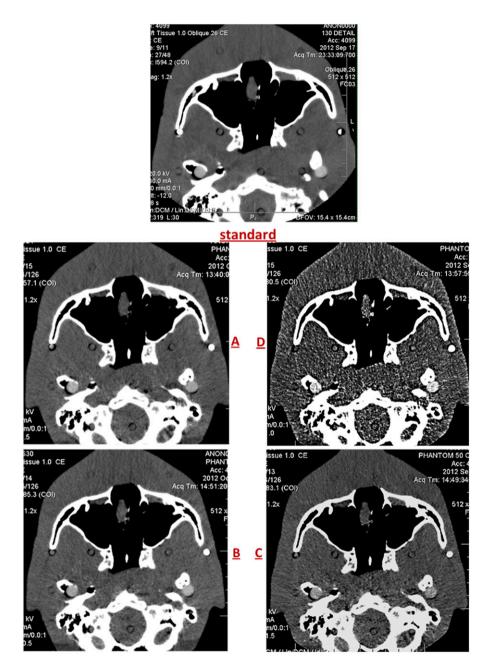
Axial sections of soft tissue window (window level and width are 40 HU and 400 HU, respectively) scanned at levels of maxillary sinus revealed the variations in image quality (image noise) of different multidetector CT (MDCT) protocols: standard MDCT protocol (Standard), (A) Protocol VII, (B) Protocol VIII, (C) Protocol IX and (D) Protocol X.
